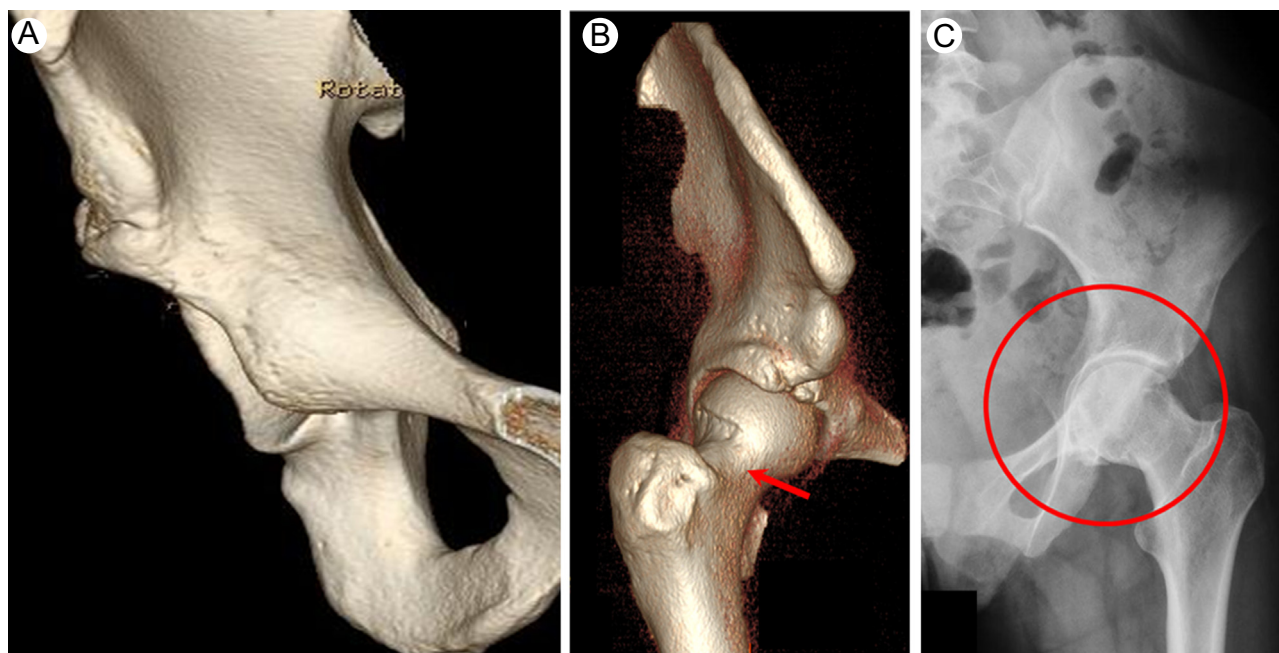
(A) A 3D CT image of the right hemipelvis reveals focal anterior acetabular overcoverage and posterior acetabular undercoverage. (B) A 3D CT image of the right hip and proximal femur exhibits coxa profunda with anterolateral cam deformity (red arrow). (C) An anteroposterior radiograph of the left hip reveals acetabular protrusion. (Color version of figure is available online.)
